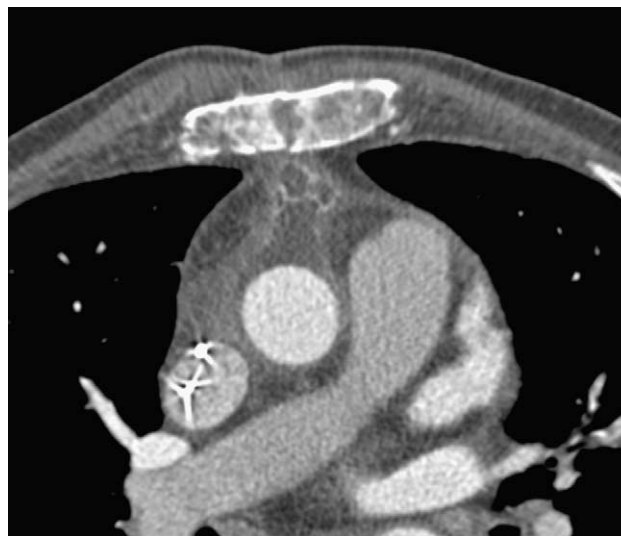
Contrast enhanced CT-scan following second look surgery displays a retrosternal mass which patterns are consistent with an abscess: high attenuation rim, which circumscribes a low attenuation multilocated collection.
